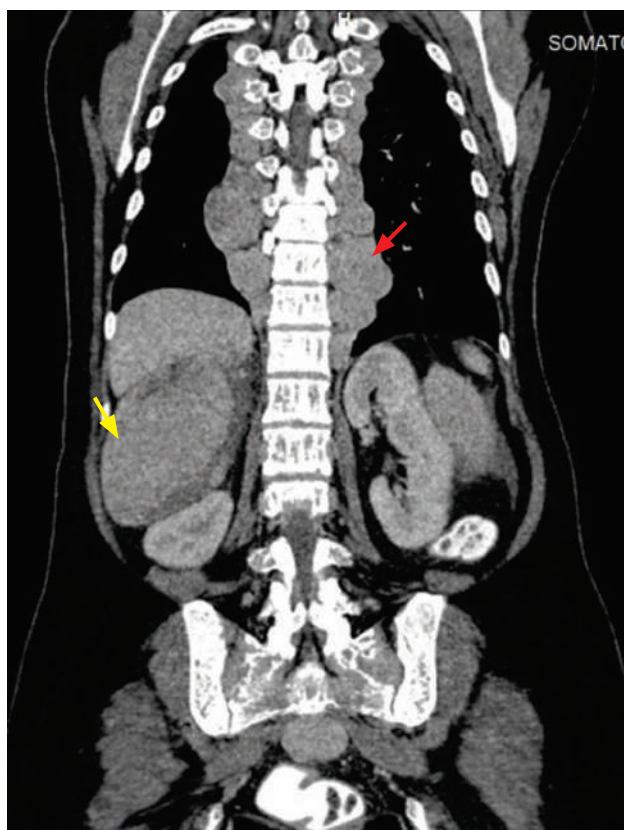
CT scan of thorax, abdomen, pelvis in 2018 revealing paraspinal mass (red arrow). Right kidney is displaced inferiorly by the huge right adrenal mass (yellow arrow).
